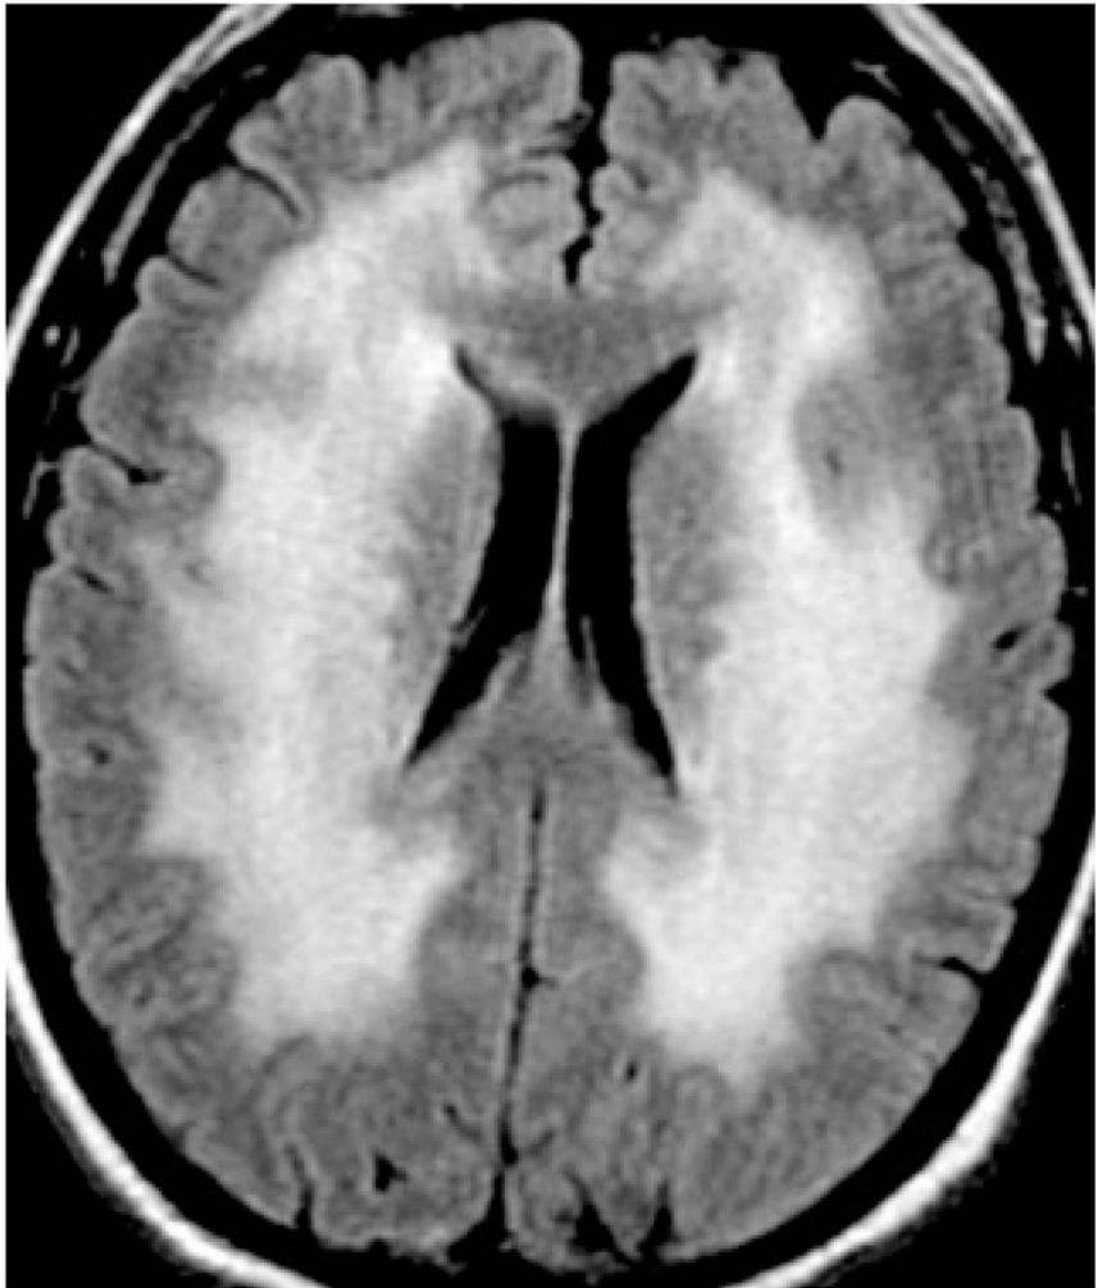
FLAIR MRI in the axial plane of a patient with cognitive decline after receiving methotrexate.²
